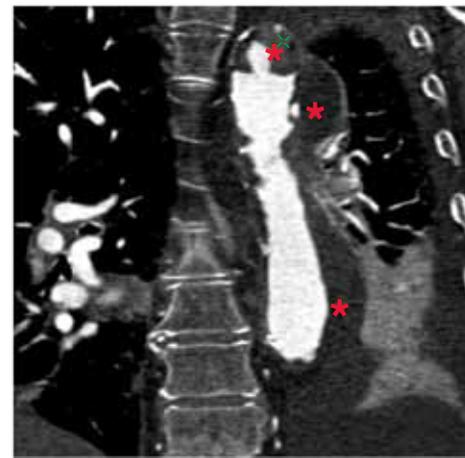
Coronal oblique CT projection of distal aortic arch and aneurysmal descending thoracic aorta in an 86-year-old female. The presence of extensive and severe atherothrombotic plaque burden along the aorta (*) is a contraindication for the transfemoral approach.
